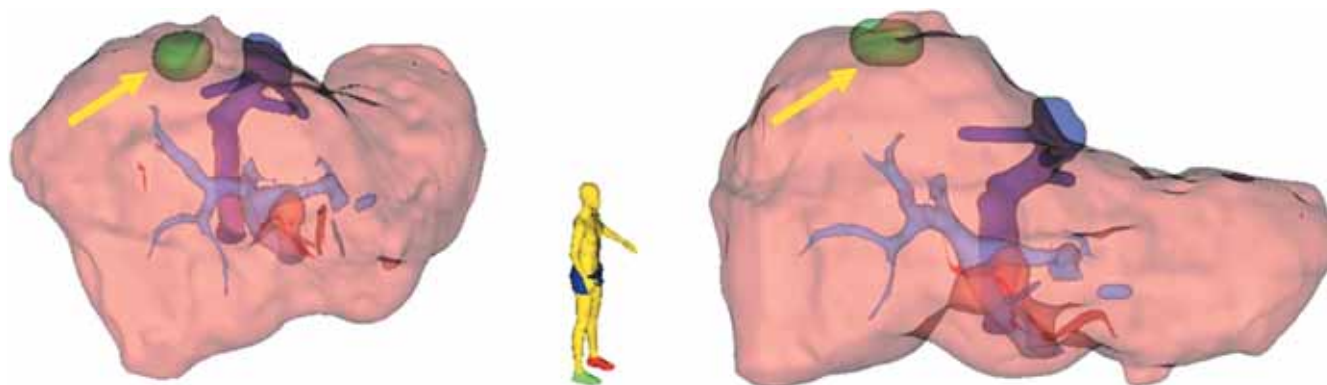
CT modeling of a focal liver graft mass in a patient. Metastasis is indicated by an arrow
